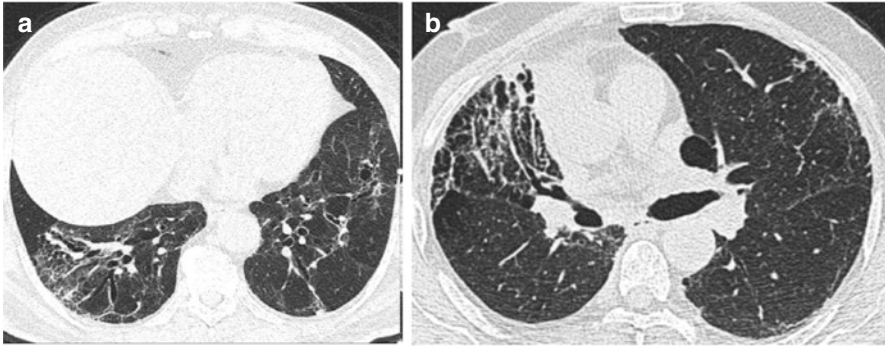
(a, b) HRCT images of two patients of COVID-19 pneumonia showing both peribronchial and subpleural areas of fibrotic-like changes
